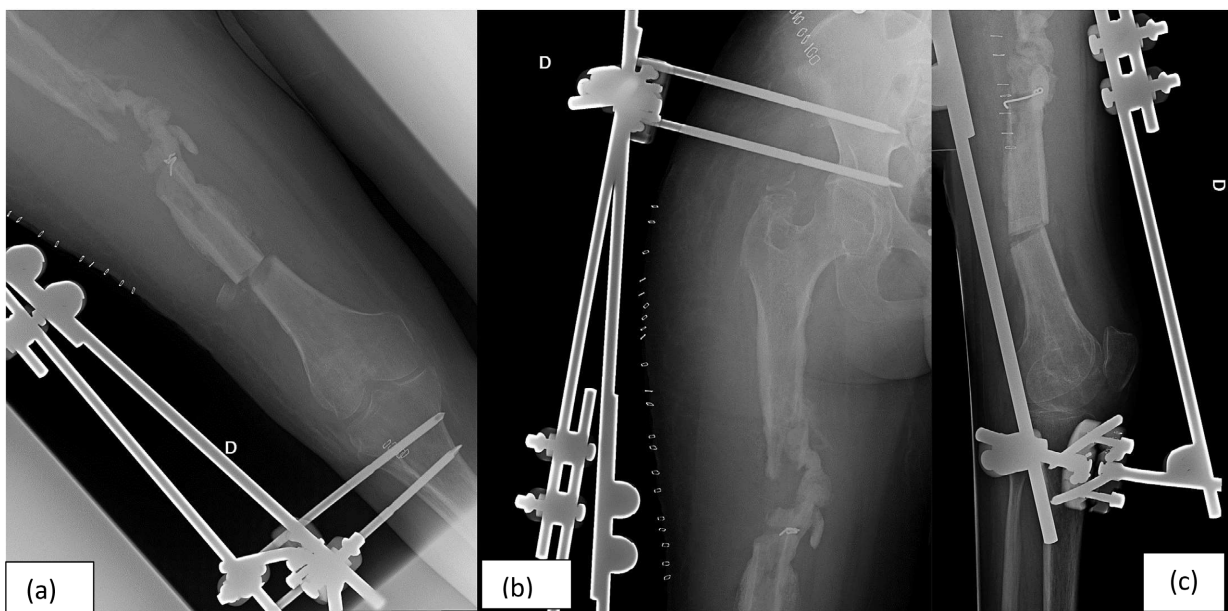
Case no. 3. Radiographs, two years after open nailing of a closed femur fracture.
